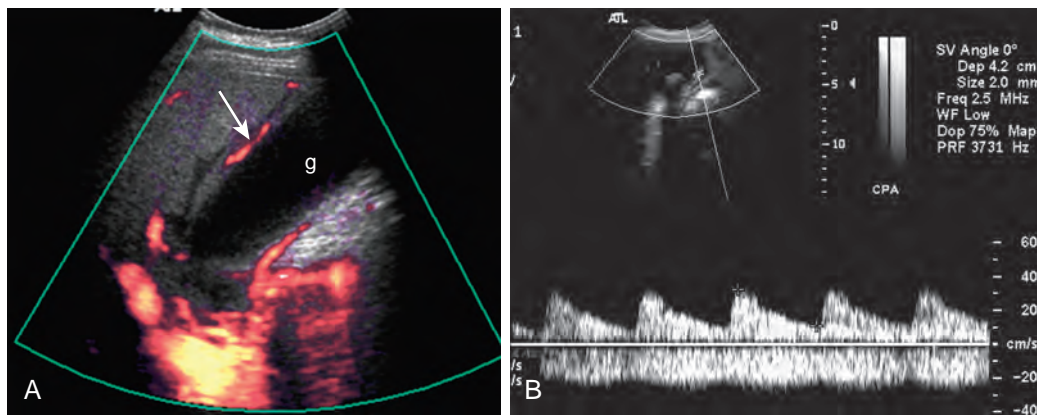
Acute cholecystitis: Doppler ultrasound. A. Sagittal scan of the gallbladder (g) demonstrates distention and wall thickening. Increased mural vascularity is demonstrated (arrow) with power Doppler. B. Spectral Doppler tracing confirms arterial waveform.
